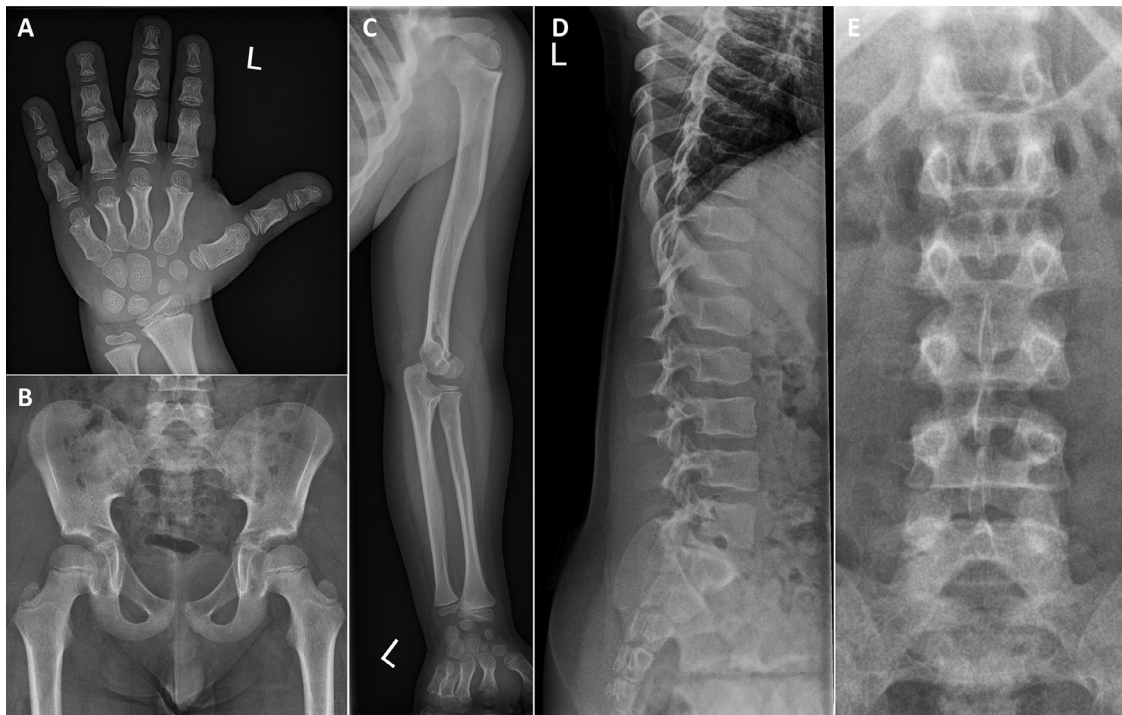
Radiographs aged nine years four months. DP left hand (A) with broadening and shortening of the bones, and significant coned appearance of the epiphyses. Anteroposterior radiograph of the pelvis (B) showing mild acetabular notching. DP left upper limb (C) showing mild mesomelic shortening. Lateral (D) and anteroposterior (E) radiographs of the lower spine with pear shaped vertebral bodies with shorter posterior than anterior heights and failure of widening of the lumbar interpedicular distances with some shortening of the pedicles.
